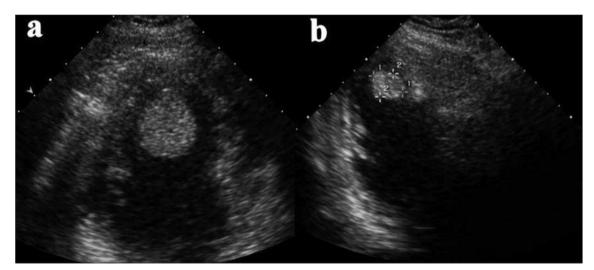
a) Preoperative transthoracic echocardiogram of left ventricle showing cardiac myxoma and its estimated size. b) Preoperative transthoracic echocardiogram of left ventricle showing recurrent myxomas.
